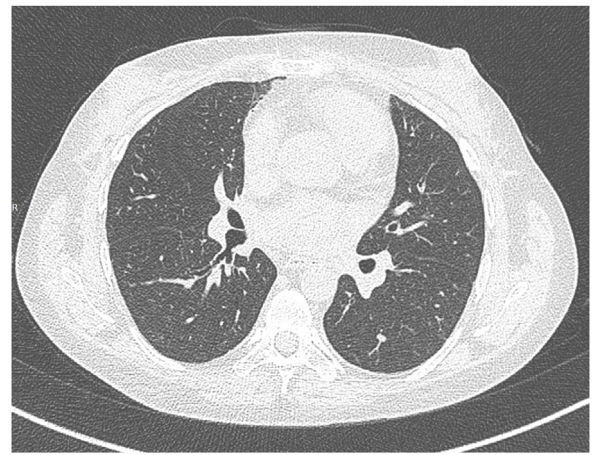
Recipient CT-scan 2 years after lung transplantation.
